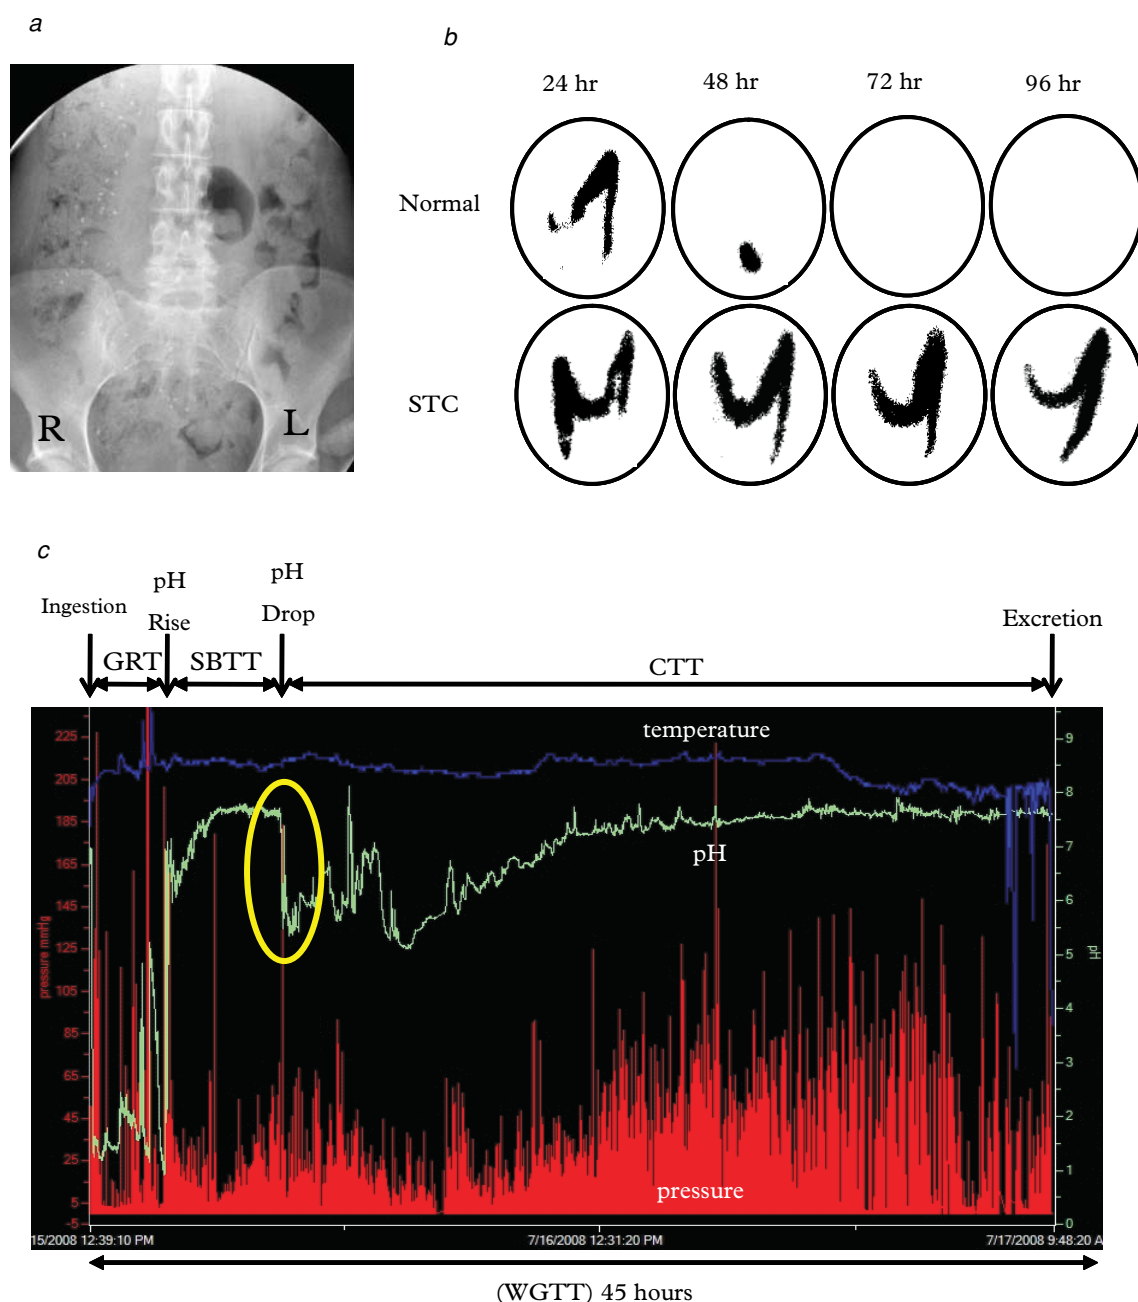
(a) Slow colonic transit: radiopaque marker study—all markers remain in the proximal colon. (b) ^{111}In isotope scintigraphy showing normal progression of isotope in a healthy control and generalized slow-transit delay. (c) SmartPill study measuring whole gut transit: progression of the capsule is determined by changes in pH and impedance. This patient has a normal colonic transit of less than 48 hours. CTT = colonic transit time; GRT = gastric retention time, SBT = small bowel transit time, WGTT = whole gut transit time.
